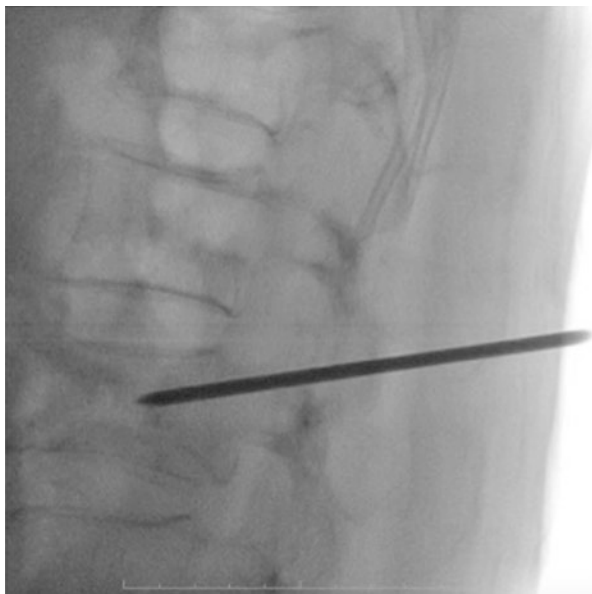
Sagittal (a) and axial (b) CT bone window images showing lytic destructive lesion involving the vertebral bodies at D1 to D3 levels. Extensive associated soft tissue is seen on axial CT (c) mediastinal window section. Presence of soft tissue makes aspiration of the lesion (d) safe as the needle need not be directed to the vertebral body and surrounding neurovascular structures. Cytopathology revealed granulomatous lesion
